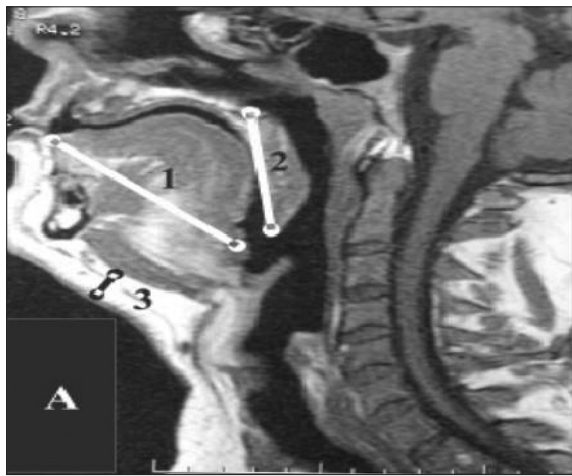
Magnetic resonance imaging sagittal section showing 1: Craniocaudal length of the tongue (maximum), 2: Craniocaudal soft palate length (maximum), 3: Submental fat thickness (maximum)
